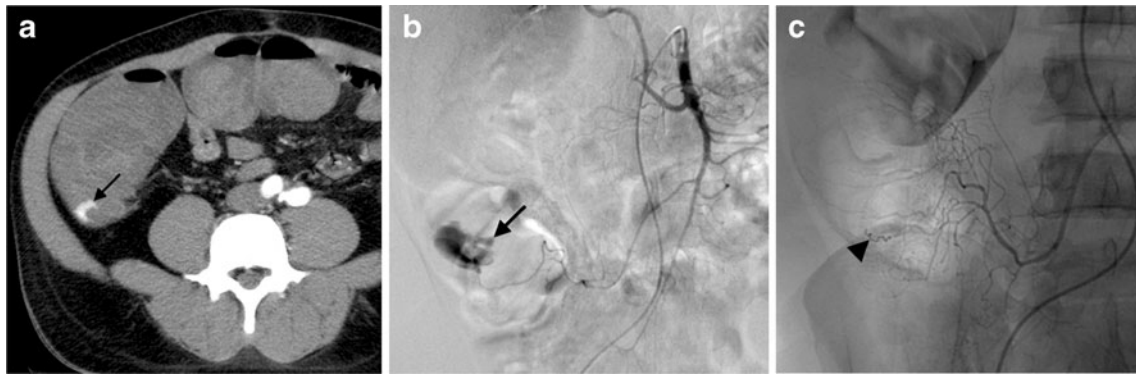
In these images, we present the case of a patient who presented an acute LGIB. This patient was treated with acetylsalicylic acid and clopidogrel for a recent cardiac ischemic event. We perform an axial CT for localization of the bleeding and after an angiography with super-selective embolization. a Axial CT image during the arterial phase shows contrast extravasation in the cecal lumen (*arrow*). b Superior mesenteric
